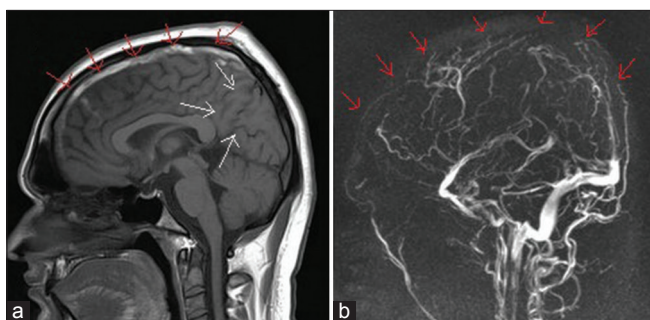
(a) Sagittal T1-images show absence of flow void with hyperintense signal in superior sagittal sinus (b) magnetic resonance imaging venography confirms superior sagittal sinus thrombosis
